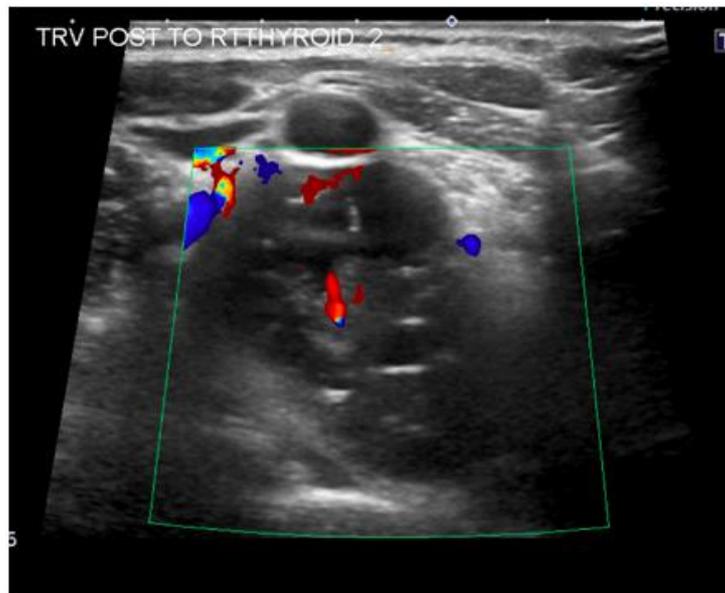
Ultrasound images of the neck at the level of the thyroid gland demonstrates vascular solid and cystic components within the lesion situated posteriorly to the carotid artery.
